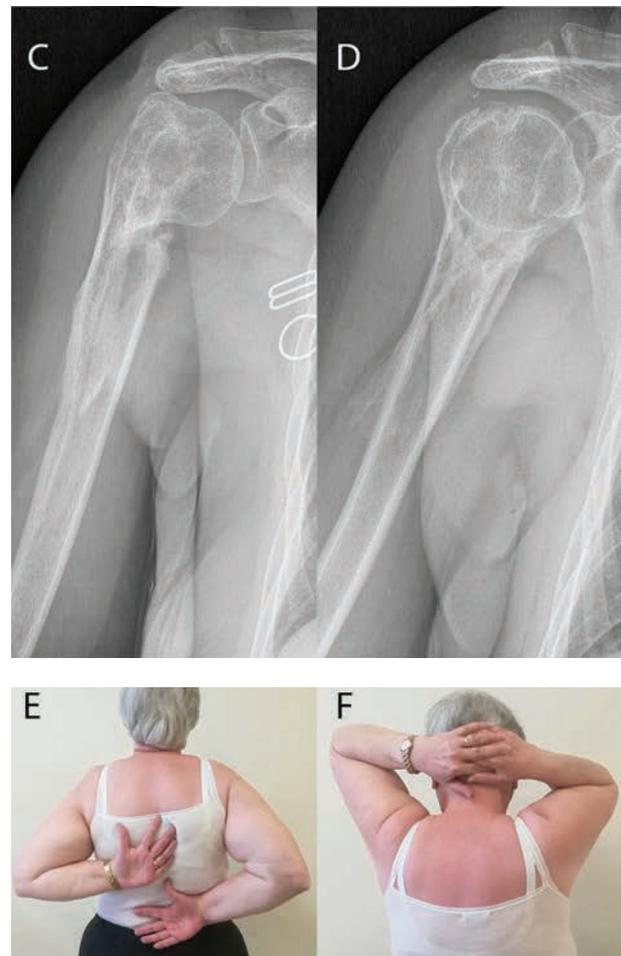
Pre-operative (A) and post-operative X- rays (B). Radiographic controls performed 11 months later (C and D). Residual limitation of ROM in maximal degrees of external rotation at clinical assessment (E and F)
